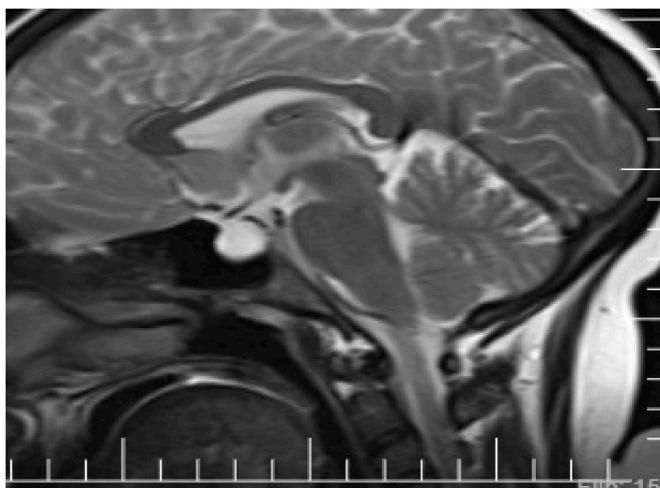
Sagittal view of pituitary MRI showing pituitary fossa filled with cerebrospinal (empty sella).
